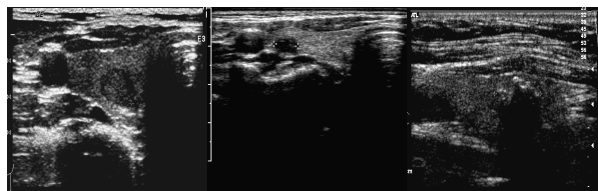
Ultrasound Image by disease
